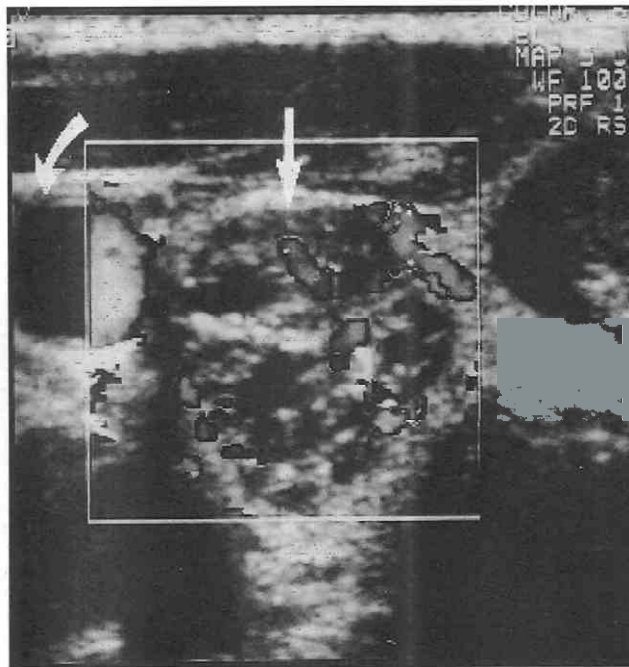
Follicular carcinoma of the thyroid. A predominantly hypoechoic heterogeneous mass (*arrow*) with central vascularity (indicated by Doppler enhancement) is seen within the right lobe of the thyroid. *Curved arrow* indicates common carotid artery.
